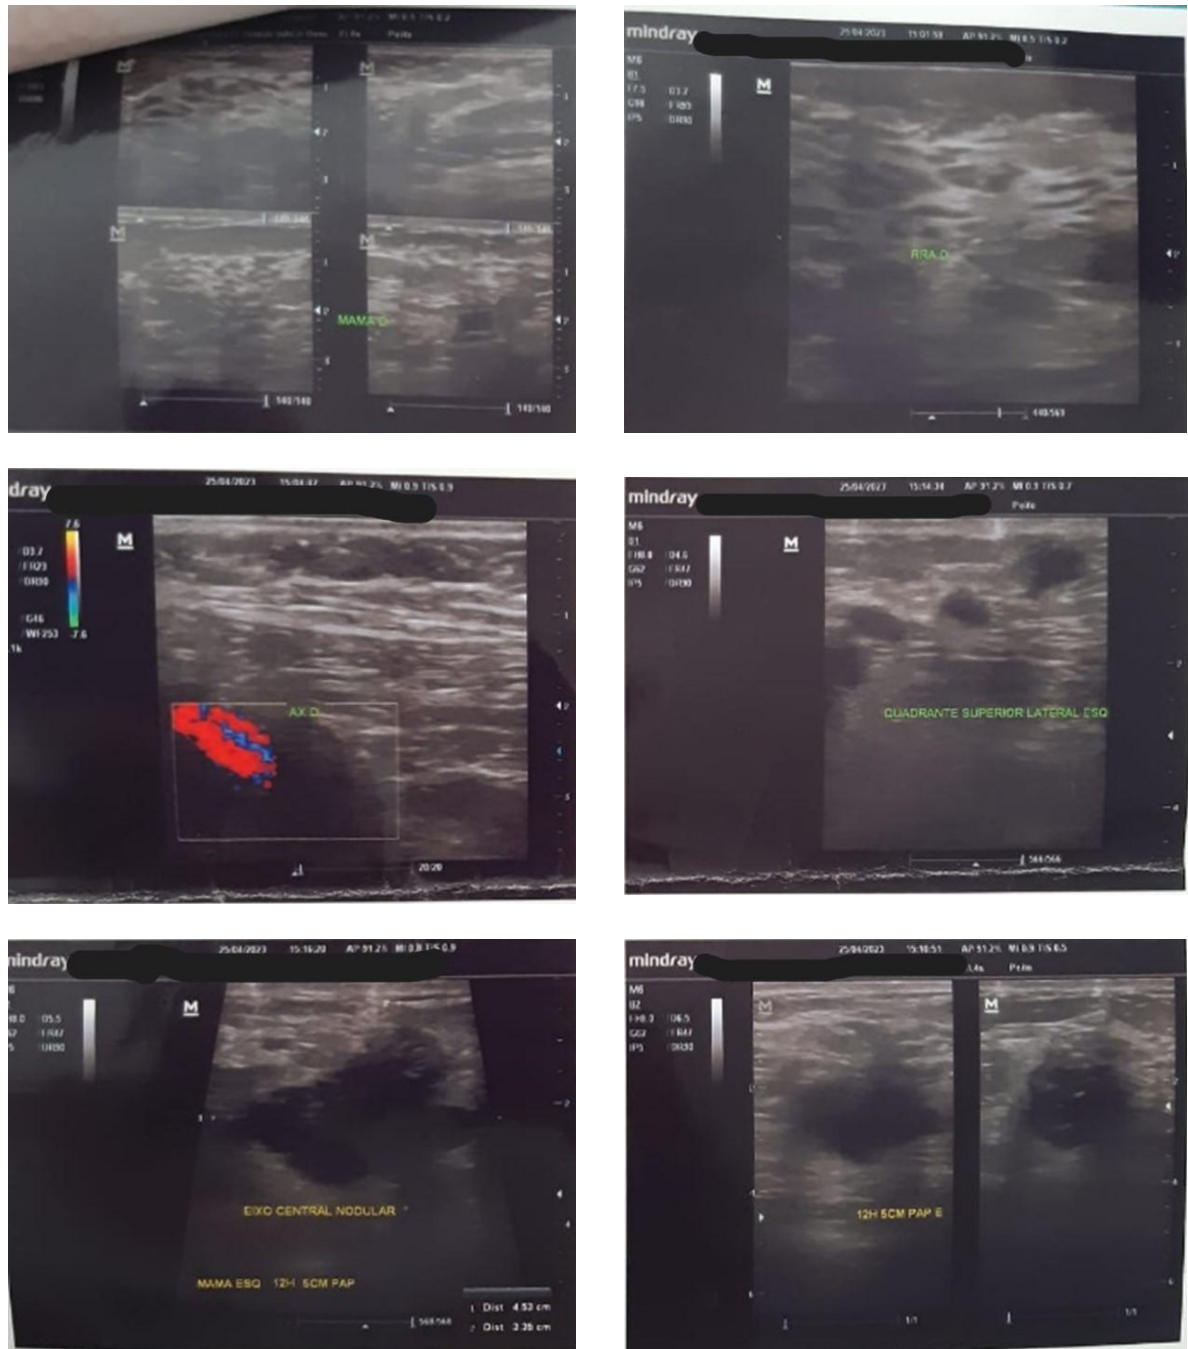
Breast ultrasound revealing a nodular image with BI-RADS 6 in the left breast, markedly hypoechoic, with irregular contours, with discrete, punctiform and peripheral vascularization on Doppler, with heterogeneous content and a combined pattern of posterior acoustic enhancement, measuring 4.53 x 3.35 cm.
